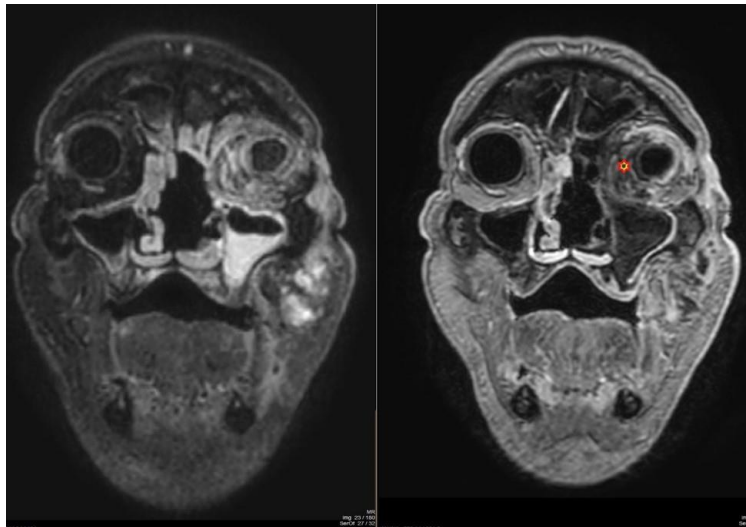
MRI brain for Case 2 (at presentation): The star indicates the left intra-orbital extension of the infection associated with exophthalmos.
